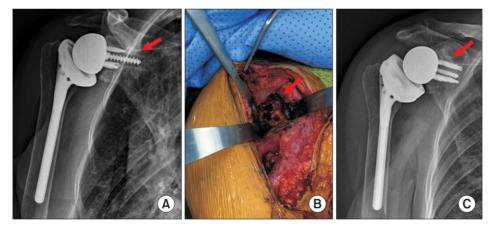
An 83-year-old woman complained of severe shoulder pain after primary reverse total shoulder arthroplasty. (A) The X-ray showed a typical screw loosening of the glenosphere (arrow). (B) The intraoperative photograph showed an enlarged screw hole (arrow) on the glenoid. (C) Revision of the glenosphere with screw change (arrow) and iliac bone graft was performed.
